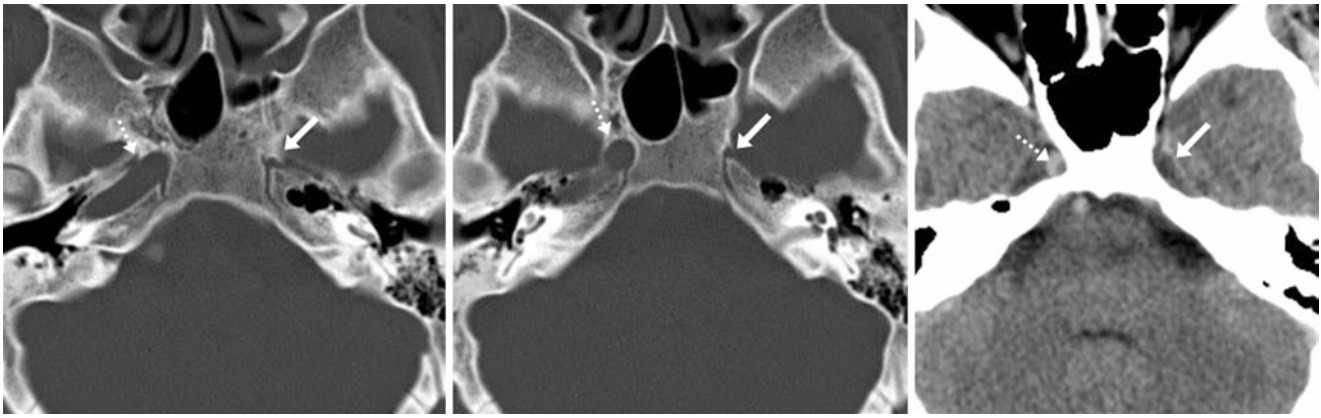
25-year-old with a hypoplastic left ICA and bony canal (arrows) on bone windows (left and middle) and a soft tissue window (right) from nonenhanced CT, performed for screening after trauma.
